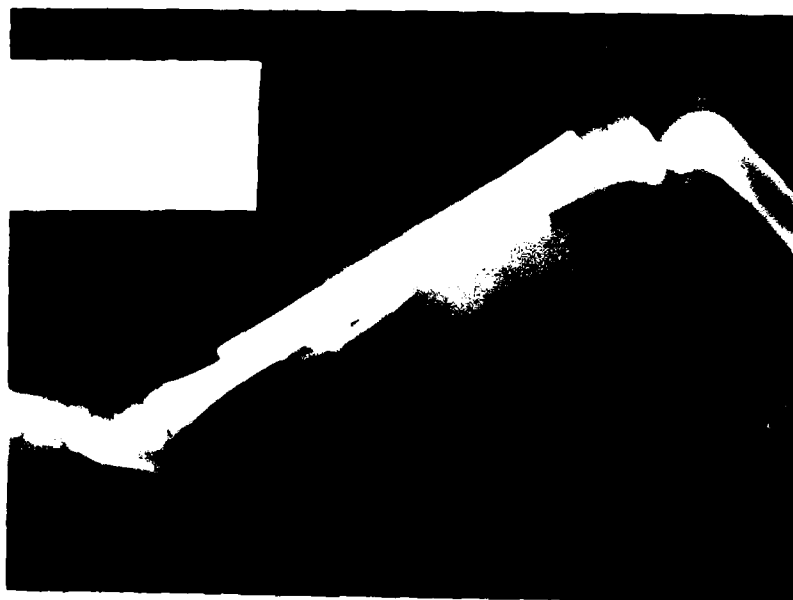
Immediate post operative X-ray of a tibial segmental replacement supplemented with bone graft.
